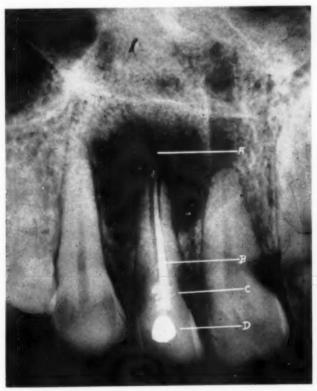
Radiograph of permanent maxillary lateral incisor showing, A, rarified area of infection; B, gutta-percha point filling root canal; C, particles of filling material in the still unrecognized internal cavity; D, filling of the lingual pit.
